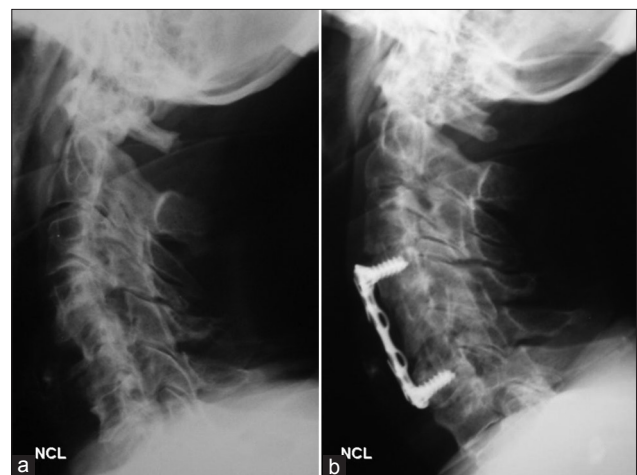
(a) Late (7.5 months) postoperative X-rays of a patient submitted to C5-C6, C6-C7 interbody fusion. The lower graft did not fuse, causing instability. (b) Following reoperation with anterior plating, a good alignment has been obtained
